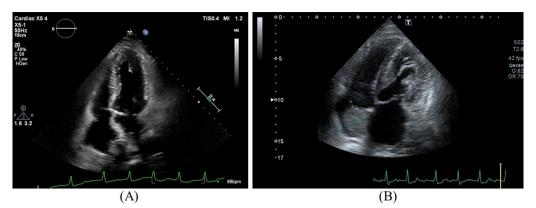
Echocardiogram image of right atrial myxoma. a Image at 9 months before diagnosis; b image at diagnosis
